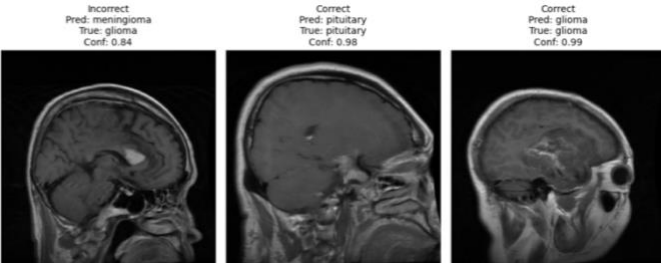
Sample predictions comparing MRI scans with their predicted and true classes, alongside confidence scores.
